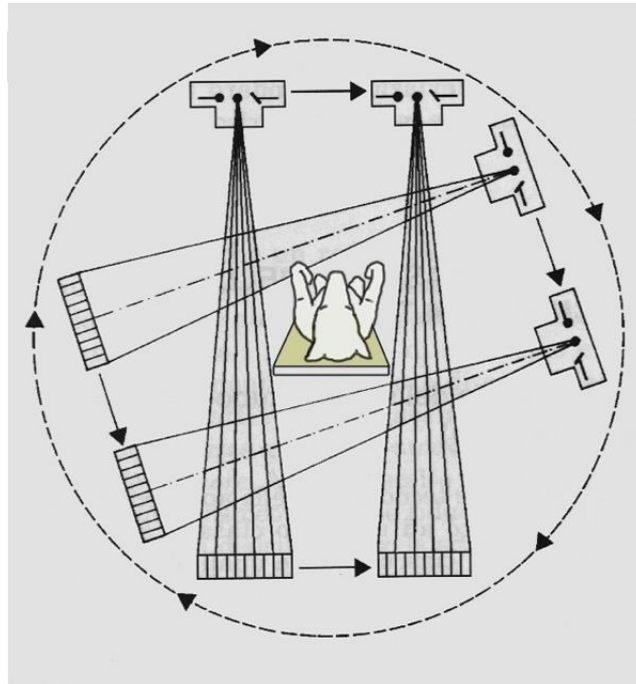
A representation of second generation CT scanner (Fan Beam, Translate-Rotate).
